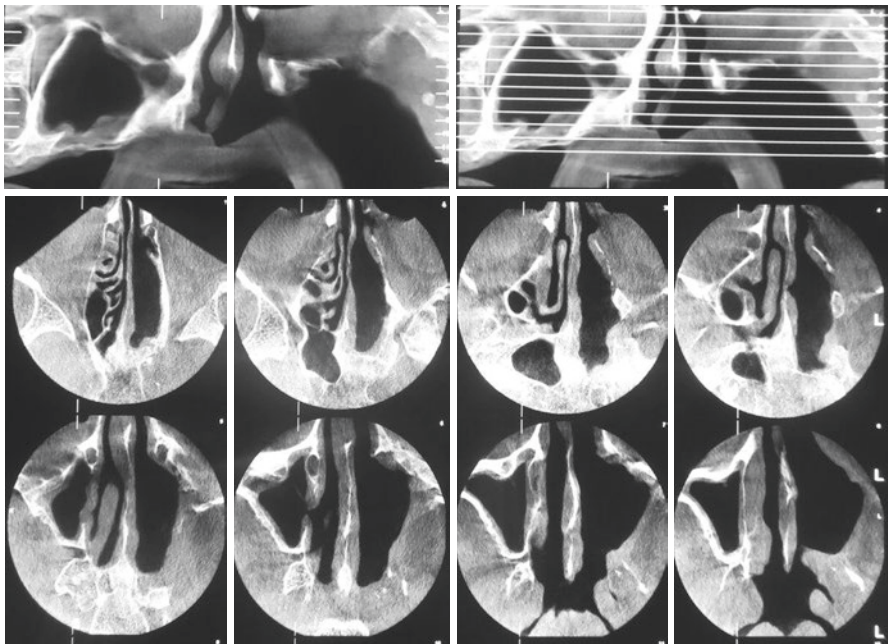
Cone-beam CT scan of a patient who has had partial maxillectomy due to an osteoradionecrosis unresponsive to treatment, shows the absence of left antrum and left maxillary basal bone. The right alveolar bone is severely atrophied and mucosal thickening in the left antrum is evident
